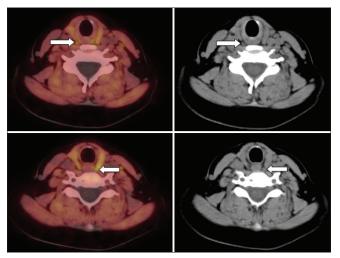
Axial ¹⁸F-FCH PET/CT images of the same patient demonstrating double adenomas, one in the right superior location (white arrow upper row) and the other in the left inferior location with significant ¹⁸F-Fluorocholine uptake (white arrow bottom row). PET/CT: Positron emission tomography/ computed tomography
